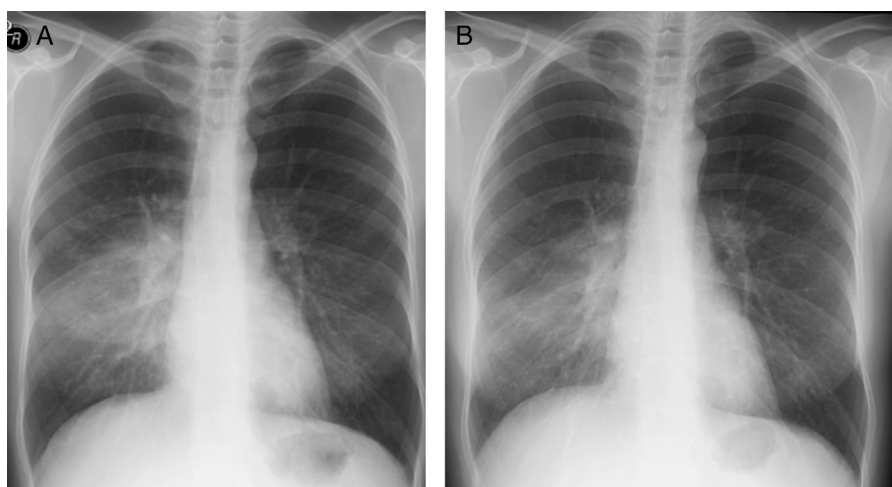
Chest X-rays at diagnosis (A) and six months after diagnosis (B). Extensive and intense infiltration with maximum intensity on the right side, in the area of segment S6 at diagnosis, and partial regression of pulmonary infiltration six months later.
